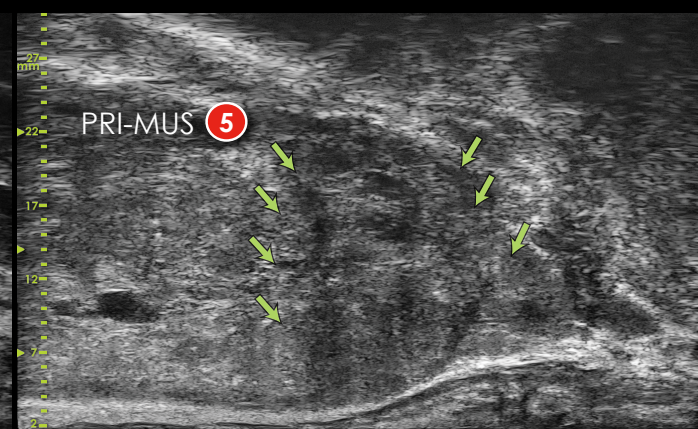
This is a micro-ultrasound image of a patient which was assigned a PRI-MUS 5 score (suspicious target with Irregular Shadowing). This core was shown to be positive on Pathology (Gleason 7). MRI missed that target assigning it with a PI-RADS 2 score
